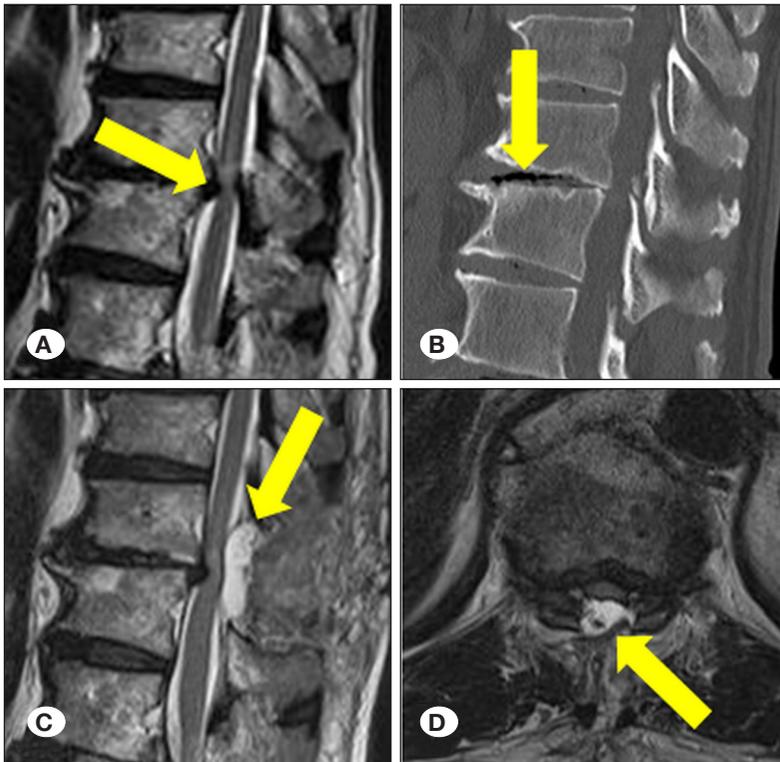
Radiographic findings of the ventral compressive lesion, vacuum phenomenon and postoperative epidural mass. Preoperative T2-weighted magnetic resonance imaging (MRI) shows ventral compressive lesion (yellow arrow) (A). Preoperative computed tomography (CT) shows the vacuum phenomenon (yellow arrow) (B). MRI shows a postoperative epidural mass (yellow arrow) that is an abnormal epidural signal change causing obliteration of the epidural space with spinal cord compression (C and D).
